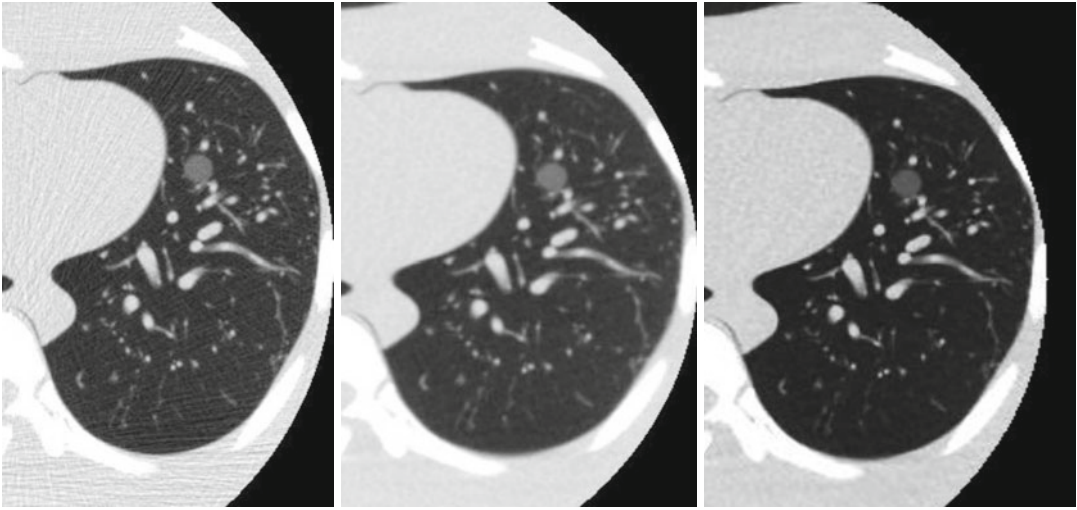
Image quality and quantity of x-ray projections
